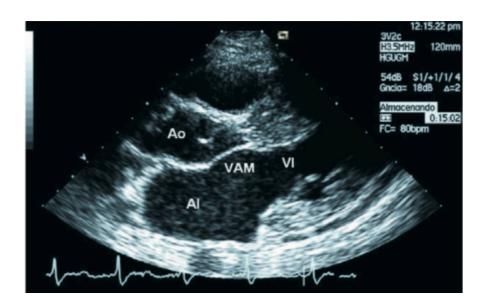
Long parasternal axis in a transthoracic echocardiography of HCM where Interventricular septum hypertrophy exist. (28)
